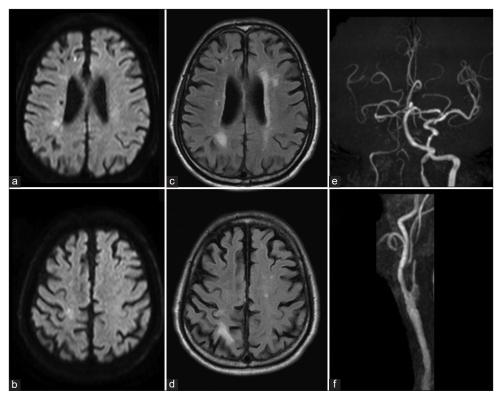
(a and b) Initial magnetic resonance imaging, diffusion-weighted image, (c and d) fluidattenuated inversion recovery image, and (e and f) magnetic resonance angiography showing acute and subacute infarcts in the territory of the right internal carotid artery (ICA) and right cervical ICA stenosis.
